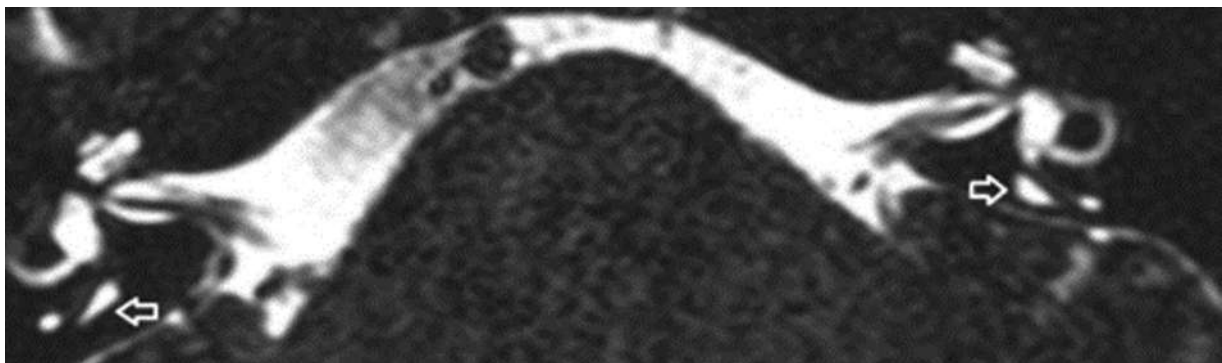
T2 DRIVE axial images show an enlarged extra-osseous sac on the left. Taken from: Connor SEJ, Dudau C, Pai I, Gaganasiou M. Is CT or MRI the optimal imaging investigation for the diagnosis of large vestibular aqueduct syndrome and large endolymphatic sac anomaly? *Eur Arch Otorhinolaryngol.* 2019 Mar;276(3):693-702. ►Figure 3.
